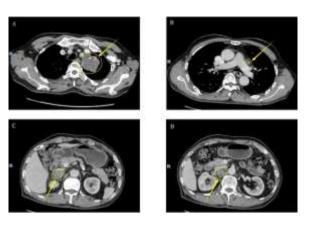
Initial computed tomography images. Computed tomography scans showing (A) left upper lung mass (5.8×5.1 cm); (B) mediastinal lymph node metastasis (1.3×1.6 cm); (C) right adrenal gland metastasis (3.3×2.5 cm), and (D) retroperitoneal lymph node metastasis (3.0×2.7 cm)
